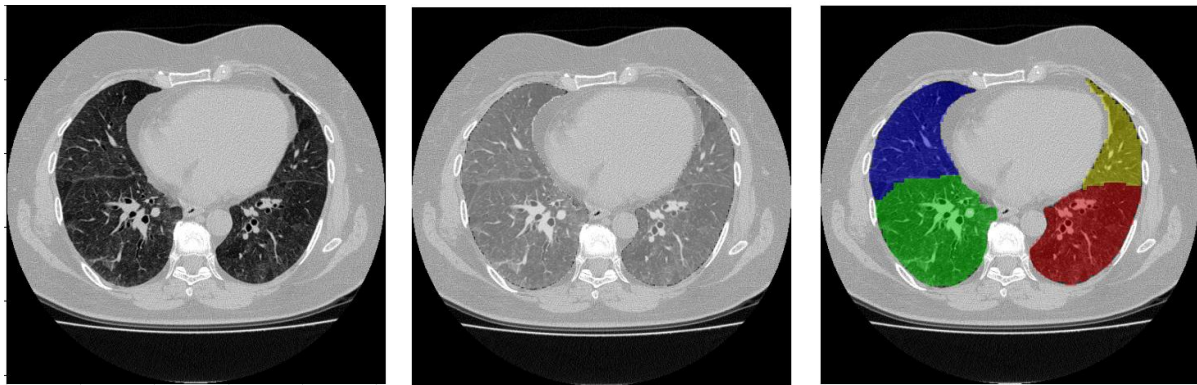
From left to right: example of lung HRCT, lung segmentation coloured in grey superimposed to the original HRCT, lobes segmentation in different colours superimposed to the original HRCT.
